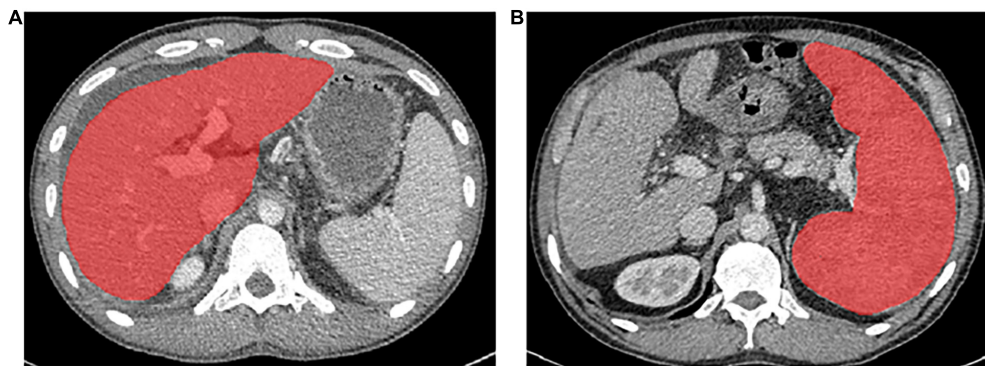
The delineation of the region of interest of the liver (A) and spleen (B) on CT images.
